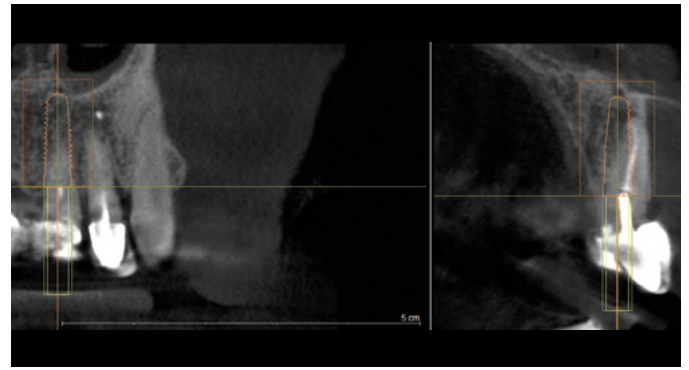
Pre-operative radiograph with implant planning
